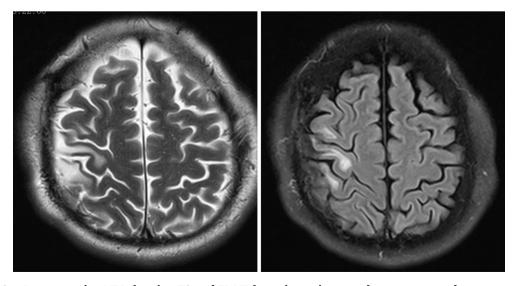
Post operative MRI showing T2 and FLAIR hyperintensity over the premotor and motor cortex.
